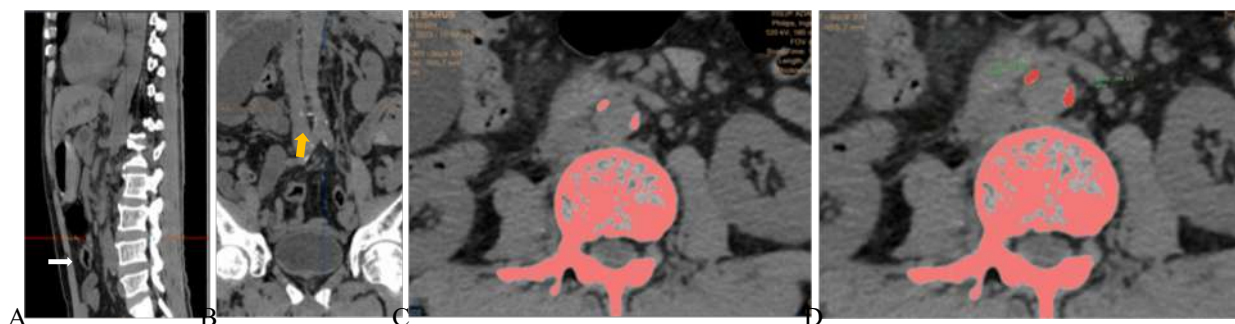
Abdominal Aortic Calcification Scoring by thr Agatston Method axial unenhanced abdominal CT image. A) Sagittal view, to assessed celiac trunk (white arrow), B) Coronal view, to assessed iliac bifurcation (yellow arrow), C) The calcification with attenuation greater than 130 HU level area colour-code pink. A region of interest in abdominal aortic is manually drawn so that only calcification are selected. D).Calcification within the region of interest are selected, and calcium score is automatically calculated according to the Agatston method.
